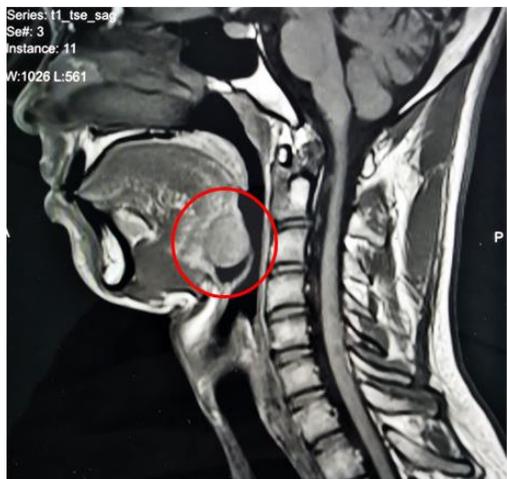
MRI Saggital view Neck
